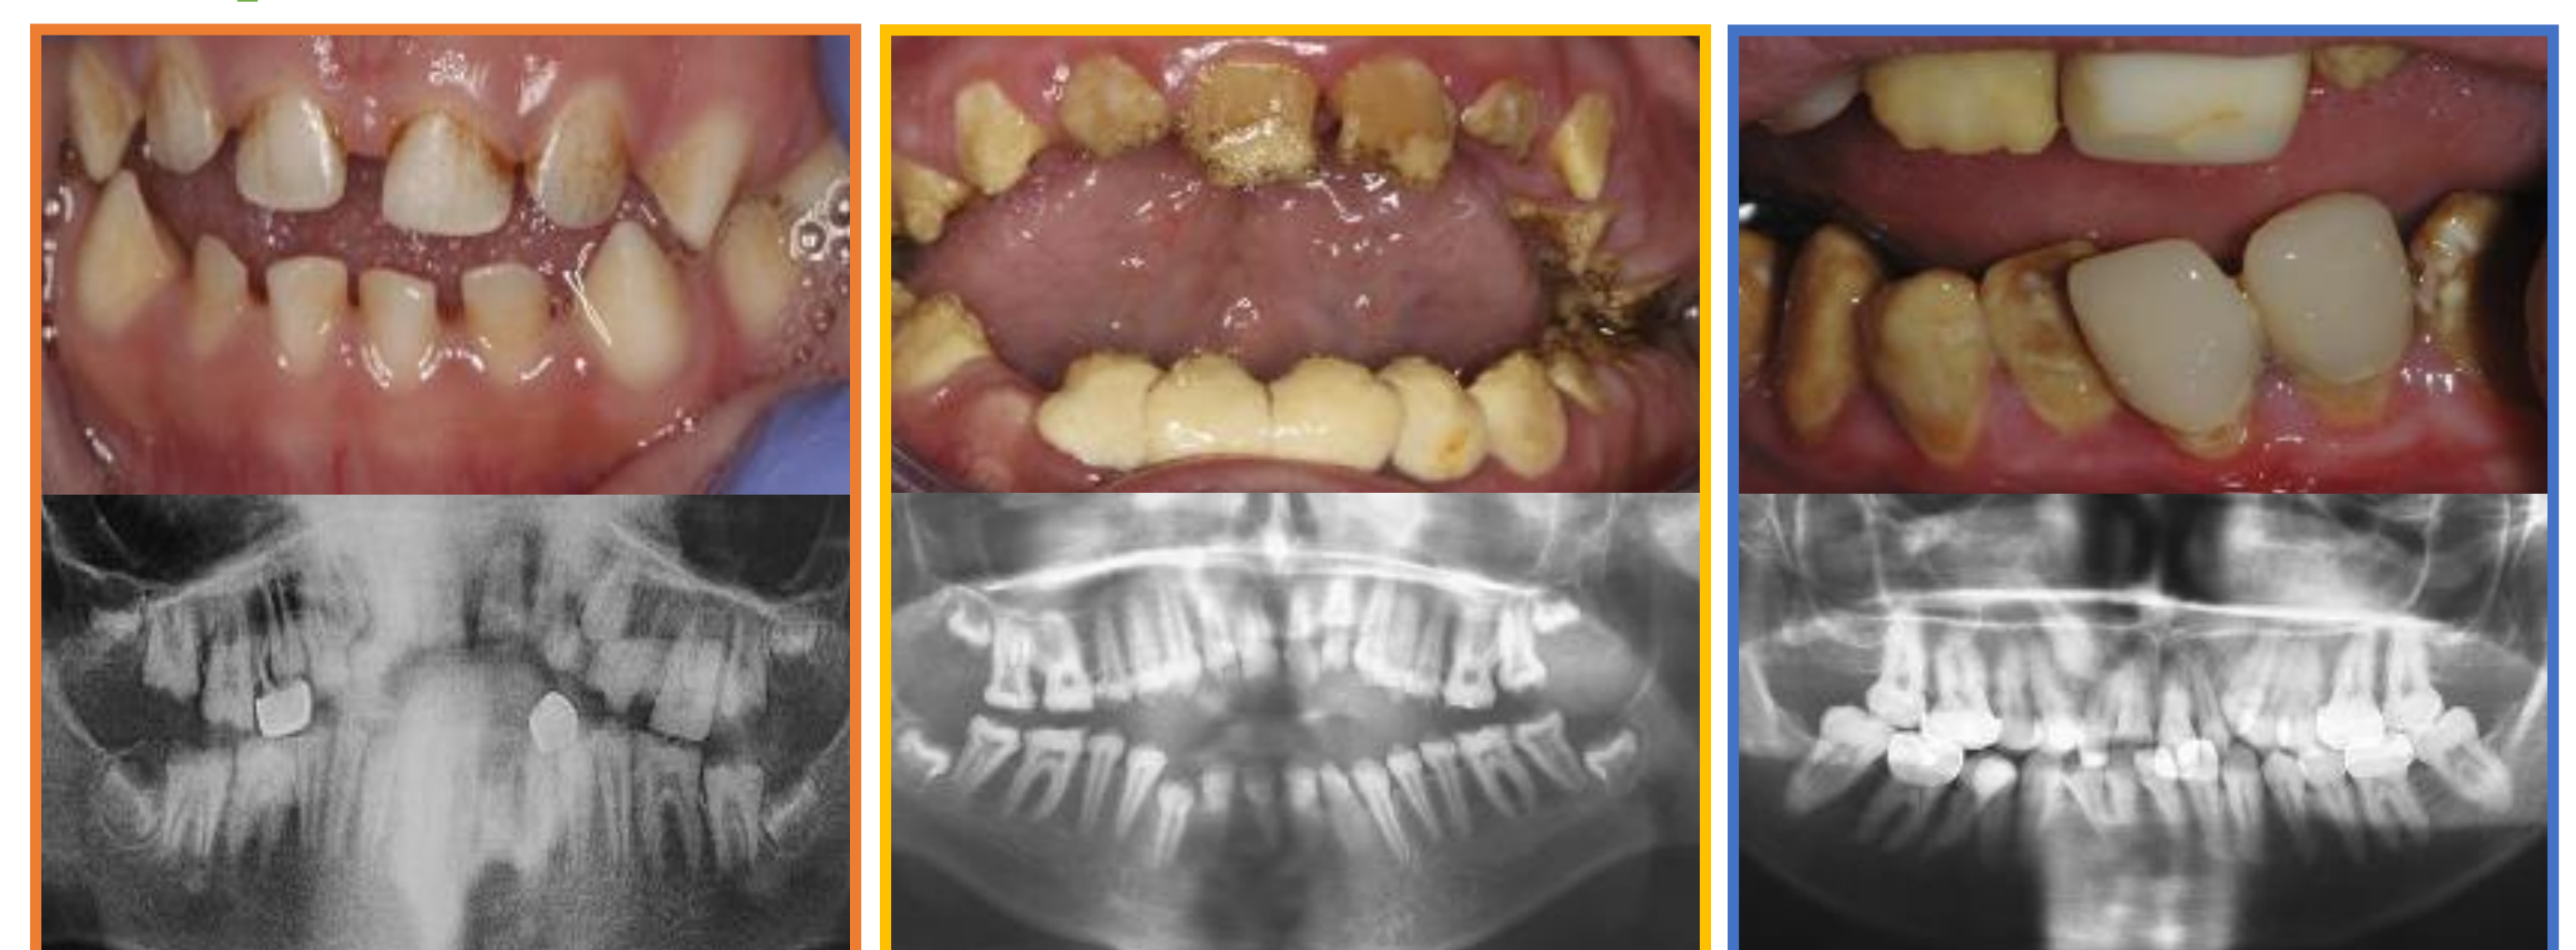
Photos and X-rays depicting the different types of AI
